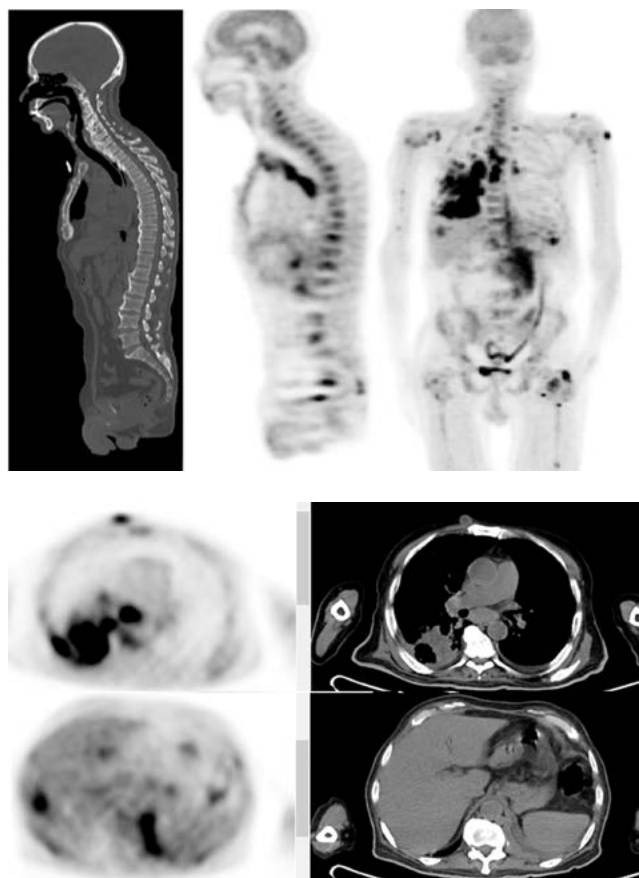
68-years-old male patient underwent restaging FDG PET-CT, which revealed FDG avid metabolically active local tumor recurrence associated with FDG avid multiple nodal, hepatic, subcutaneous nodules, bilateral pulmonary nodules, and widespread bone/ bone marrow deposits. First row images could represent the absence of textural bone changes on CT images that appeared definitely infiltrated on PET images. Rest of images showed bilateral supraclavicular nodal involvement, active small right anterior chest wall nodule (easily missed on CT scanning alone), and active liver deposit
